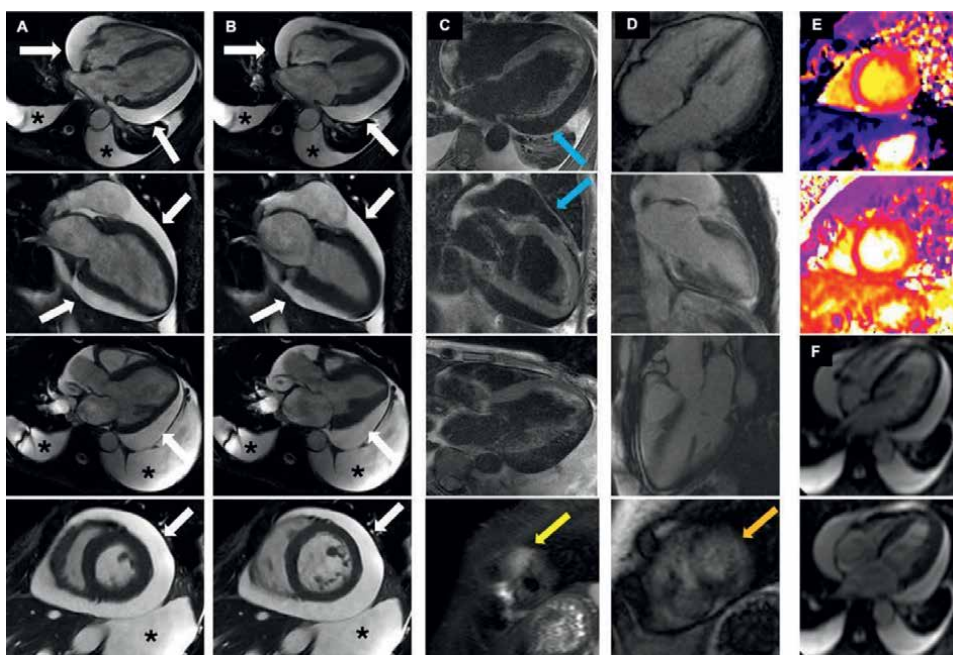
CMR study at 3 T of a 41 y.o. woman with PSS and pericardial effusion saw in follow-up transthoracic echocardiography. CMR was requested to rule out acute myocardial inflammation. Cine images in (top to bottom) the 4-chamber, 2-chamber, 3-chamber, and mid-short axis views (A) and corresponding end-systolic cine (B), STIR (C) and late gadolinium (D) images. Native T1 (top) and T2 (bottom) maps are shown in (E). Left and right ventricular volumes were normal as well as left ventricular mass without any regional wall motion abnormalities. No myocardial edema was detected. No late gadolinium enhancement was seen. The pericardium of normal thickness and signal intensity but mild pericardial effusion was observed (arrows) with transudate characteristics (native T1 356ms) and no signs of hemodynamic compromise.
